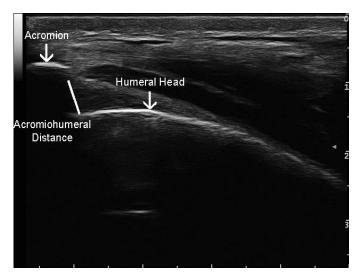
Ultrasound image shows the shortest tangential measure between the hyperechoic landmarks of the most superior aspect of the humerus and acromion.
